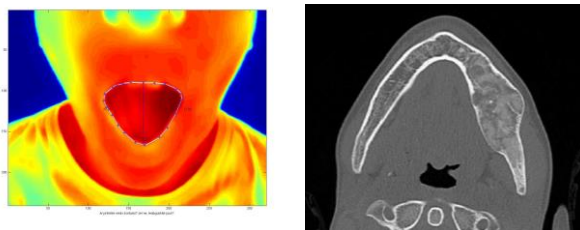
Thermo graphic image of patient face with tumour (abnormal area highlighted in dark red in mouth cavity) and CT image of tumor
